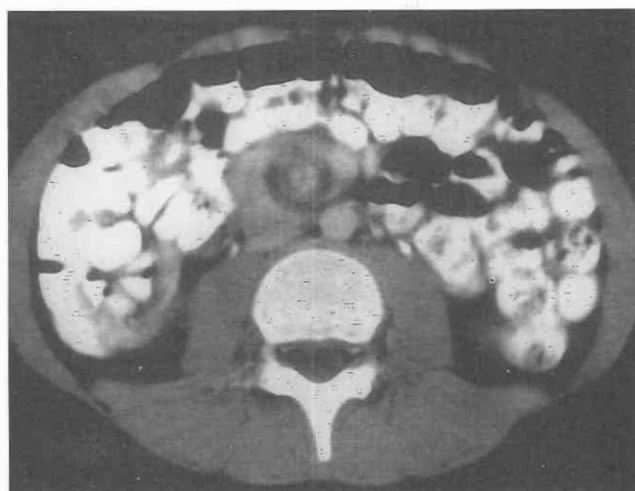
Midgut malrotation. CT scan through the midabdomen of a patient with midgut malrotation and volvulus demonstrates twisting of the small-bowel mesentery around the superior mesenteric artery.
